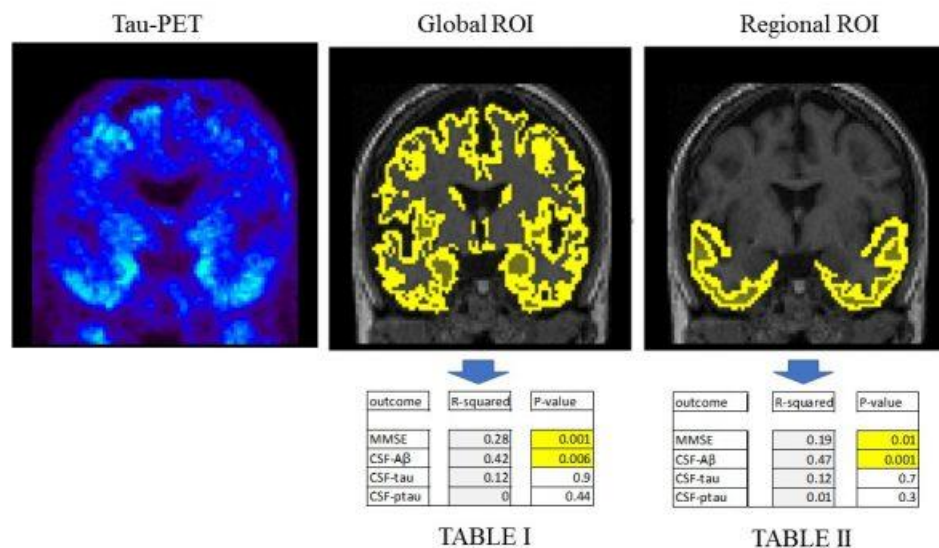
Global and regional ROIs were applied on AV-1451 images. The regional ROI included medial temporal lobe, transentorhinal cortex, fusiform gyrus, superior temporal gyrus following Schwarz et al. 2016. Associations between SUVR values and other biomarkers are presented in TABLES I & II.
